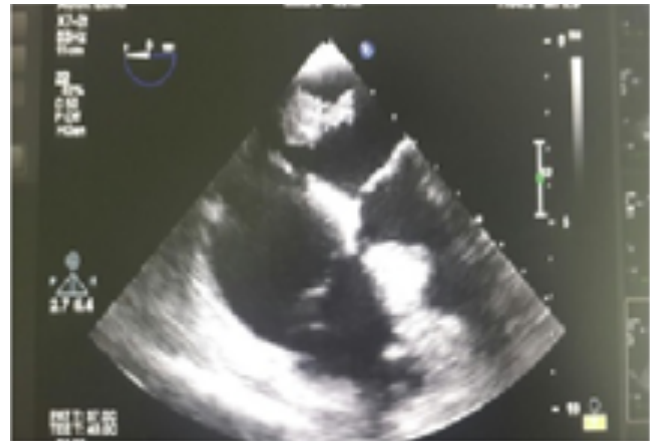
Echocardiographic imagine of myxoma
